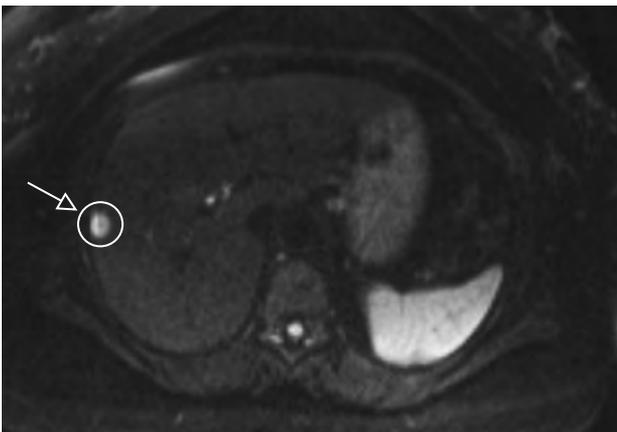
Follow-up magnetic resonance imaging of the hepatic area. In segment VII of the liver, a 1.6×1.5-cm hyperintense lesion on the fat-suppressed T2-weighted image was noted subcapsularly (hypointense on the T1-weighted image, no contrast uptake).
